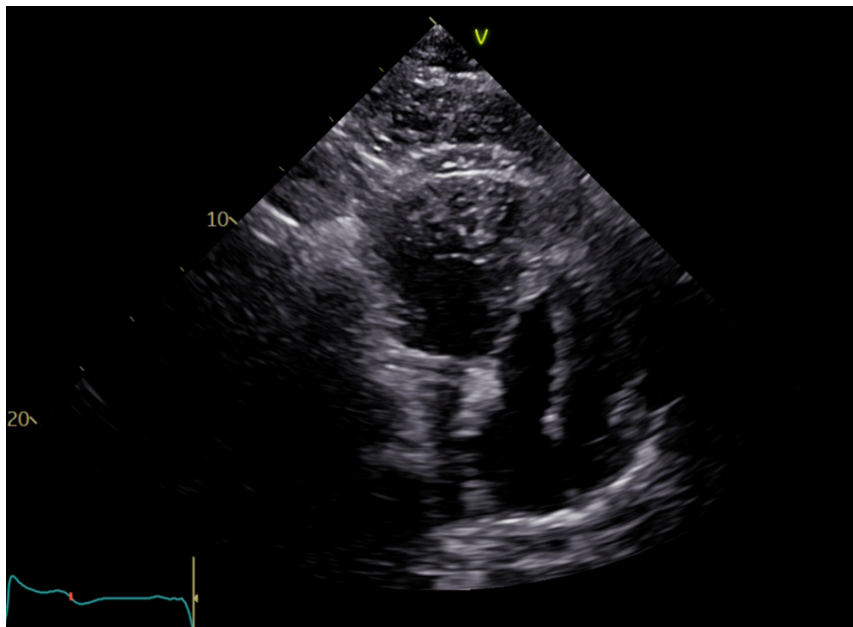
Post-procedural echocardiography revealing an ejection fraction of 50% with mild mitral and tricuspid regurgitation.
